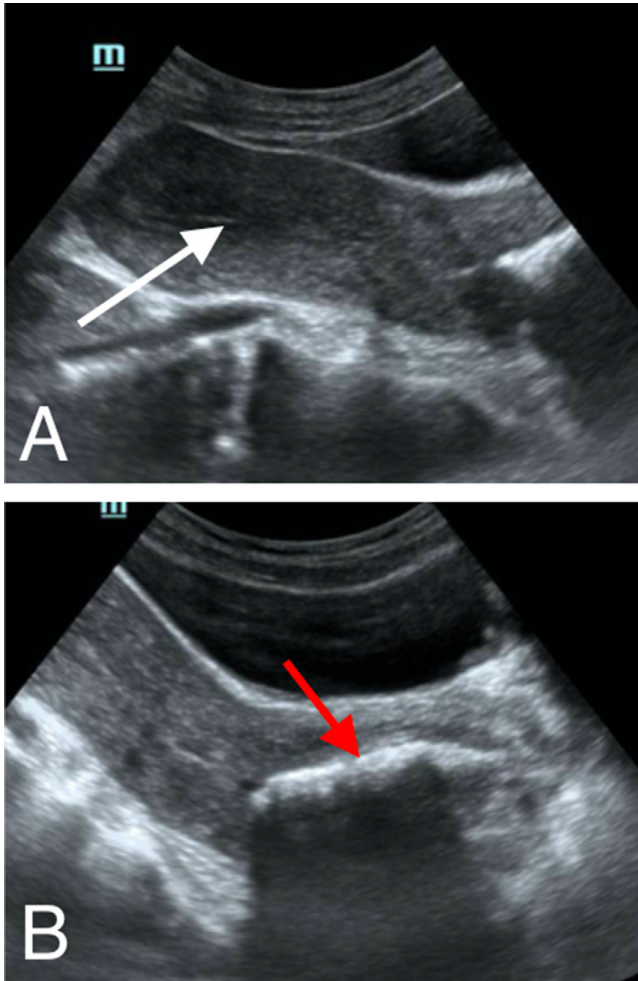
Transabdominal pelvic ultrasound. (A) longitudinal section passing through the uterus, showing complete evacuation of the uterine cavity (white arrow). (B) longitudinal section passing through the vagina showing an empty cavity of fluid but containing air bubbles responsible for a posterior artifact (red arrow).
